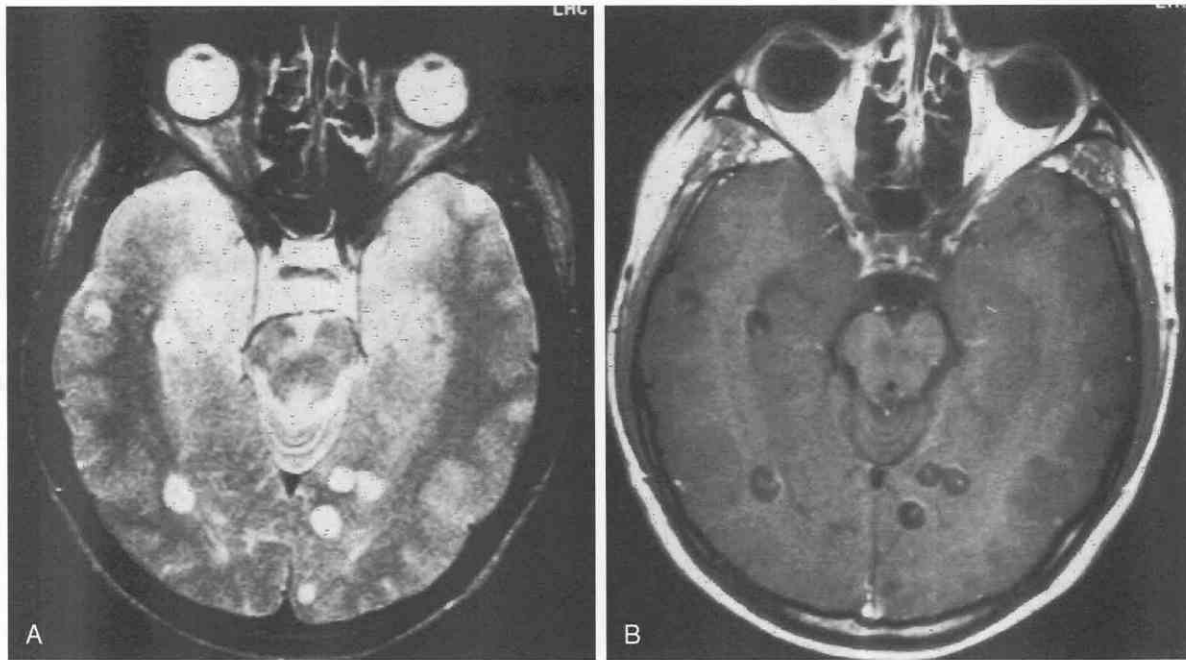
Parenchymal cysticercosis. *A*, T2-weighted image shows multiple high-signal-intensity lesions. *B*, Gadolinium-enhanced image shows multiple low-signal-intensity lesions with an eccentric isointense scolex. A few of the cysts show partial enhancement of the cyst wall.
